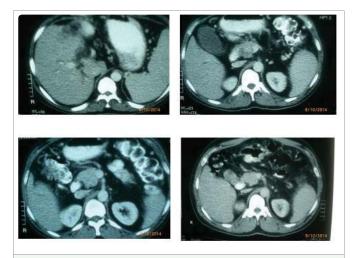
Contrast enhanced abdominal CT scan showing mass in the head of the pancreas with its close relationship to superior mesenteric vein. Also seen is the distended gall bladder.
